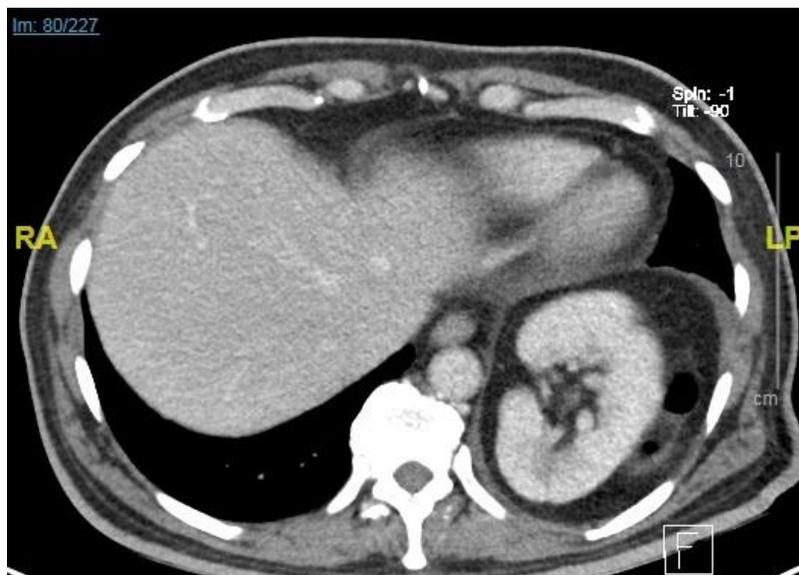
Axial view on CT imaging
